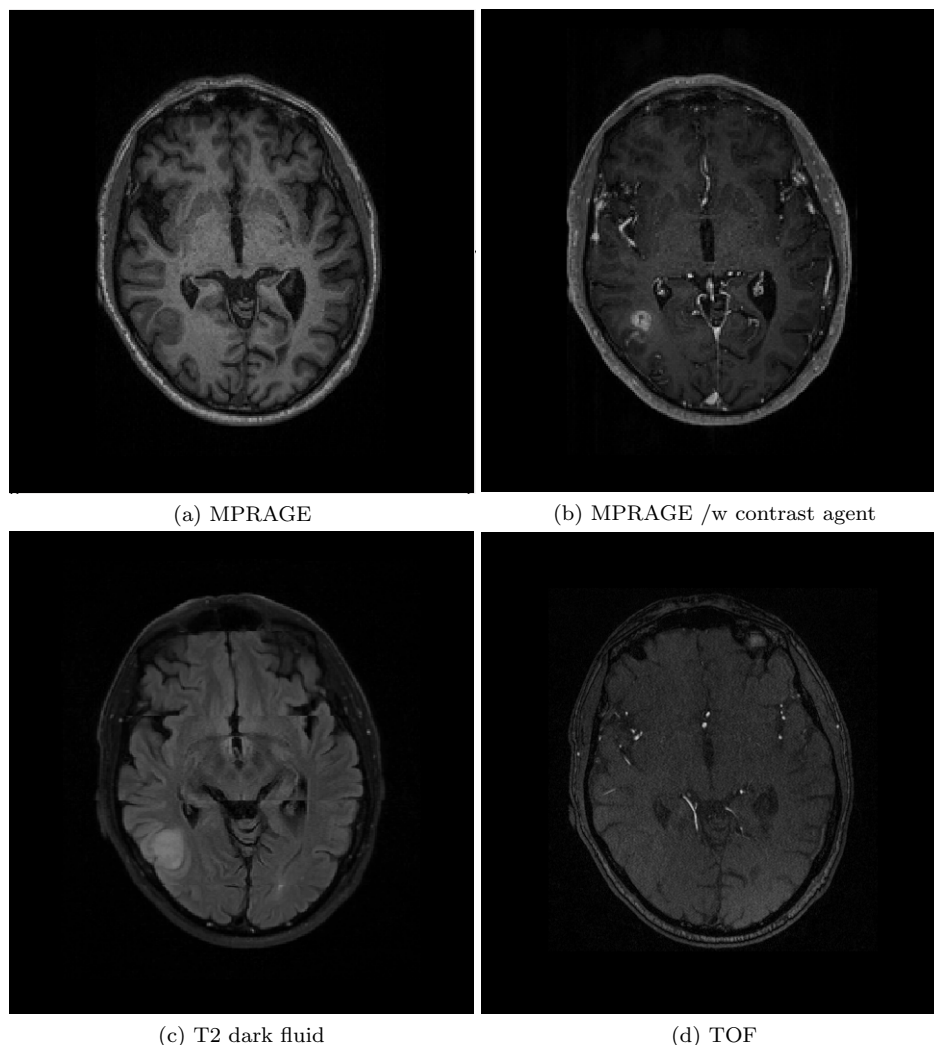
Examples of different MR images: (a) magnetization-prepared pulses and rapid gradient-echo (MPRAGE) T1-weighted sequence, yielding good tissue contrast; (b) MPRAGE with contrast agent, improving contrast in lesion; (c) T2-weighted image, fluid is dark; (d) time-of-flight (TOF) image revealing angiographic detail.
